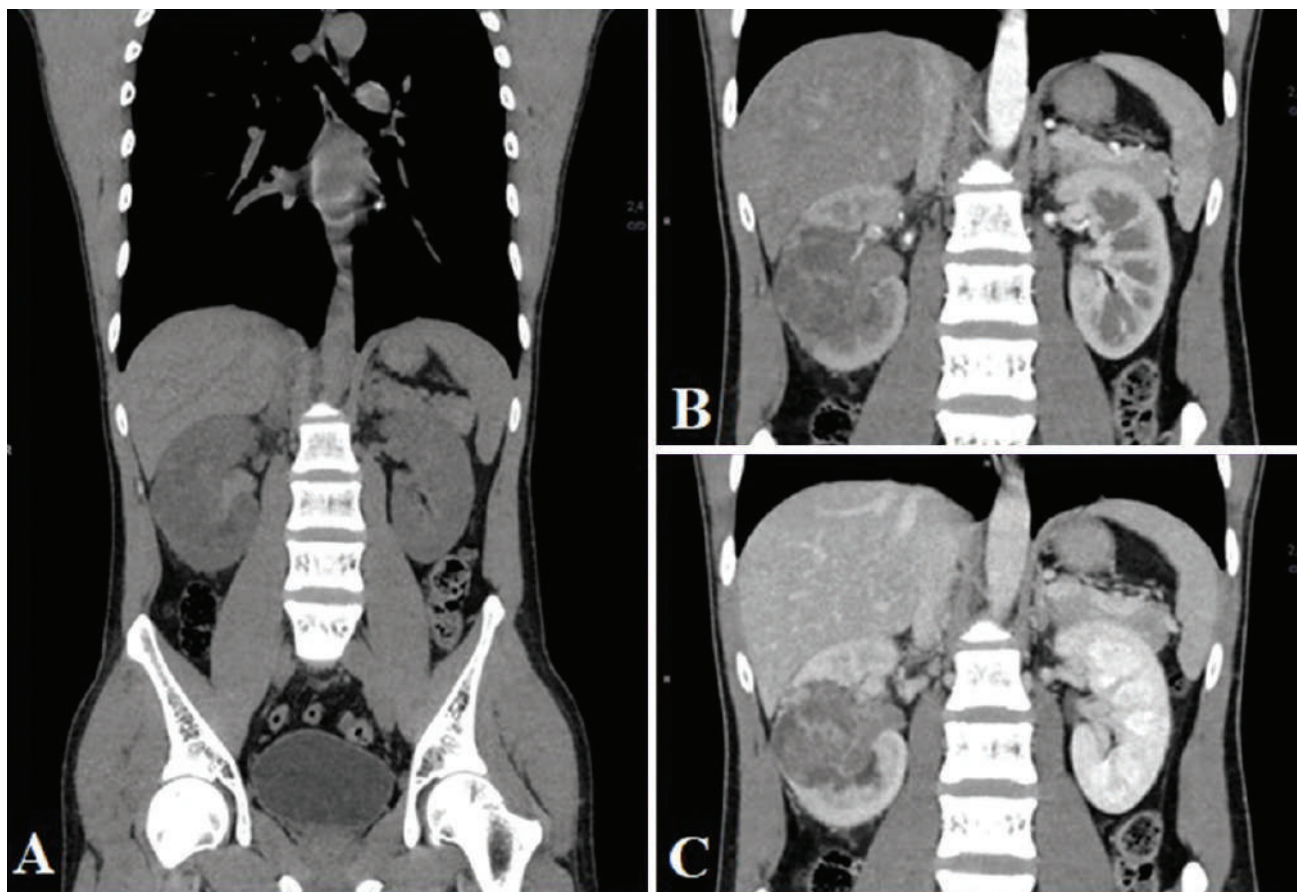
Triple-phase CT scan (A) plain, (B) arterial phase, (C) venous phase showing a heterogeneously enhancing, endophytic renal mass involving the infundibulo-calyceal system.
